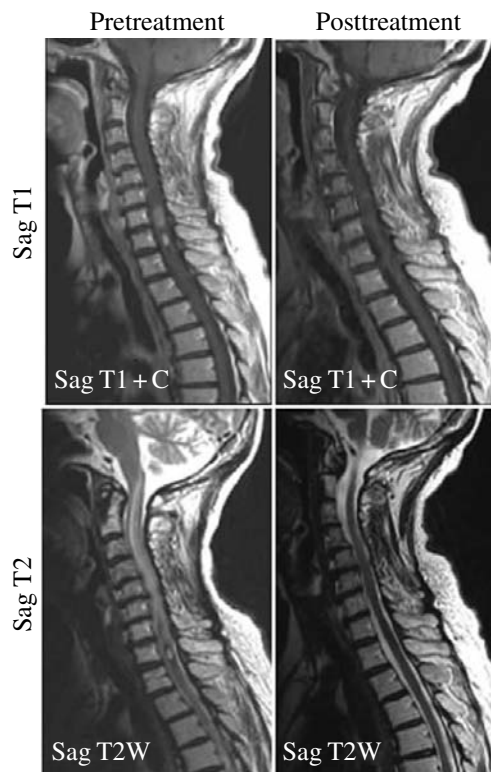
CTLA-4 blockade results in significant tumor regression in some patients. MRI images of the cervicothoracic spine from a patient with metastatic malignant melanoma which reveal enhancing intraspinal metastases with extensive cord edema prior to treatment with CTLA-4 blockade. Posttherapy images demonstrate complete resolution of the metastases and the accompanying edema. (adapted from Hodi et al. [96]).
